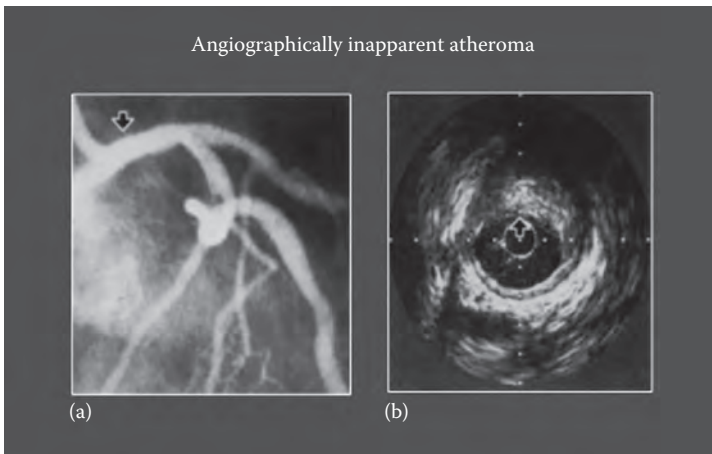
Coronary heart disease that is not detectable by angiogram (a) is clearly evident using computed tomography (b). (From Nissen, S.E. et al., in *Topol [Ed.], Interventional Cardiology Update*, 14, 1995.)
